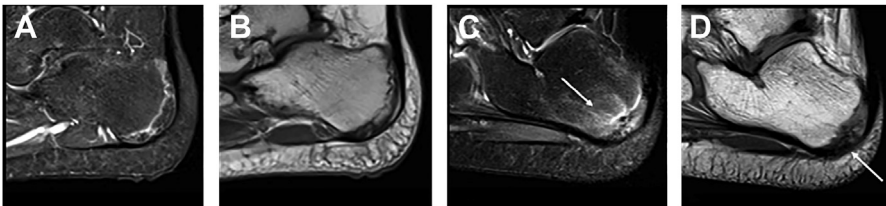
Normal apophysis versus apophysitis (Sever)—normal calcaneus apophysis in a 13-year-old boy (A, B), with a fragmented aspect that is normal during developmental ossification identified on T2WFS (A) and T1 (B) MR images. Another apophysis in a 10-year-old boy with hindfoot pain (C, D), showing mild sclerosis accompanied by bone marrow edema (arrows) that extends to the adjacent calcaneus tuberosity, on T2WFS (C) and T1 (D) MR images signs that support the diagnosis of apophysitis in this clinical scenario.
